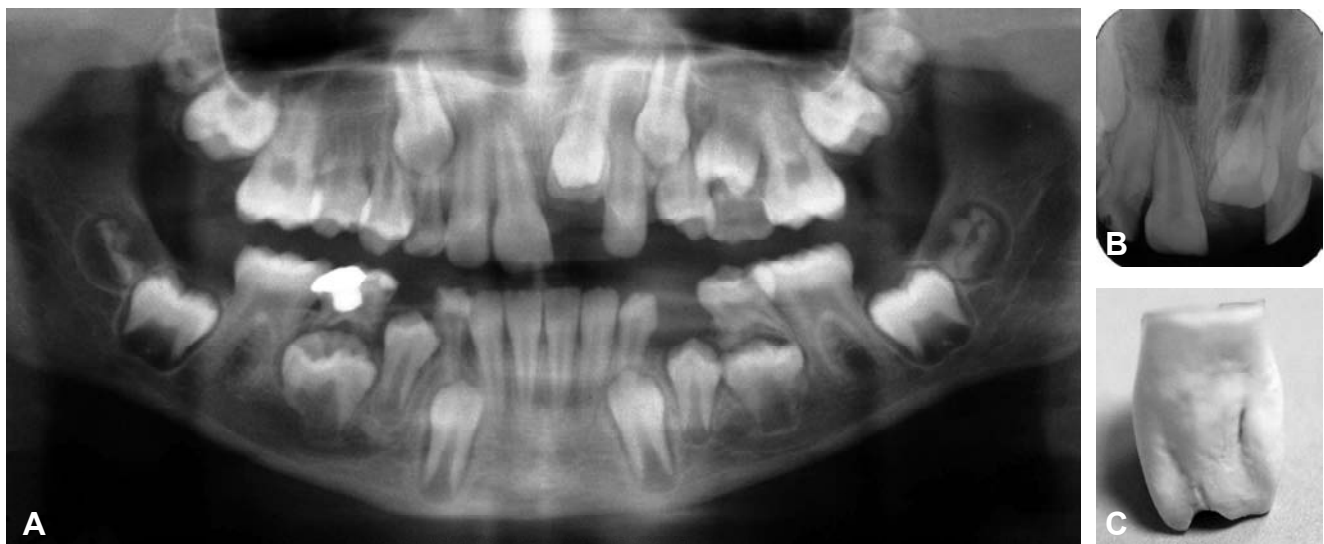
Impacted central maxillary incisor due to supernumerary tooth: A – orthopantomogram with impacted upper left central maxillary incisor; B – intraoral roentgenogram with clear view of supernumerary tooth; C – supernumerary tooth.
